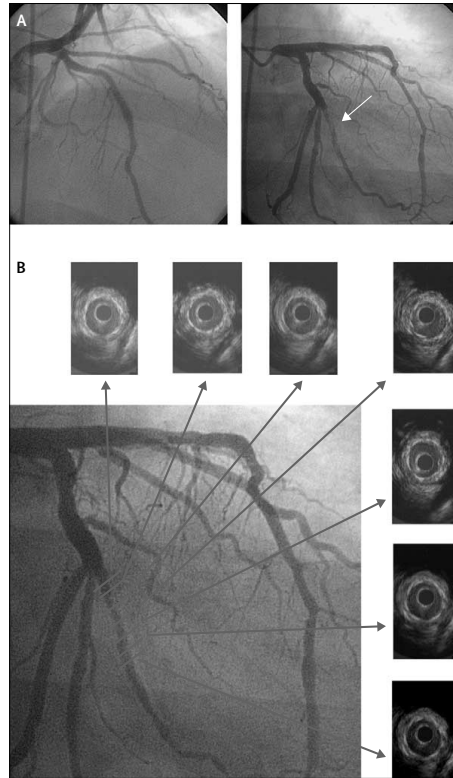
Angiographic and intravascular ultrasound images on presentation with stent thrombosis in a patient previously treated with sirolimus-eluting and bare-metal stents
